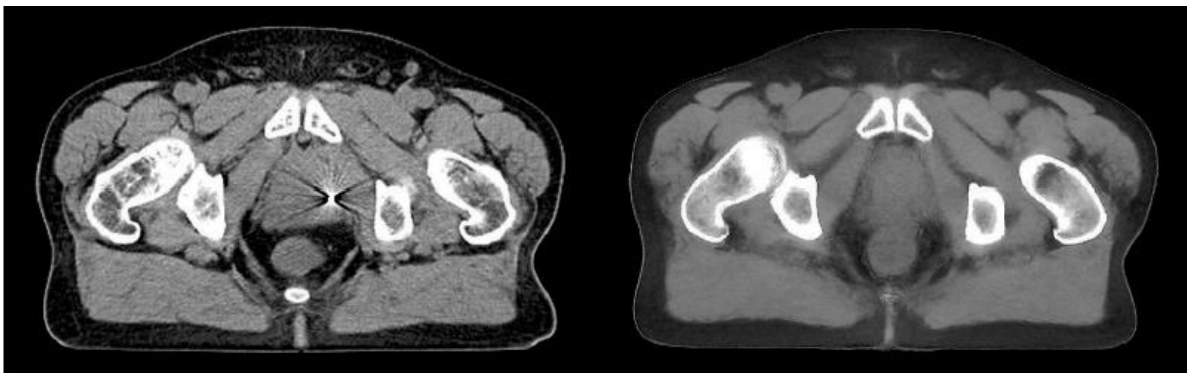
Conventional CT image on the left and sCT image generated from T2 weighted MRI on the right (Gustafsson, 2019)
